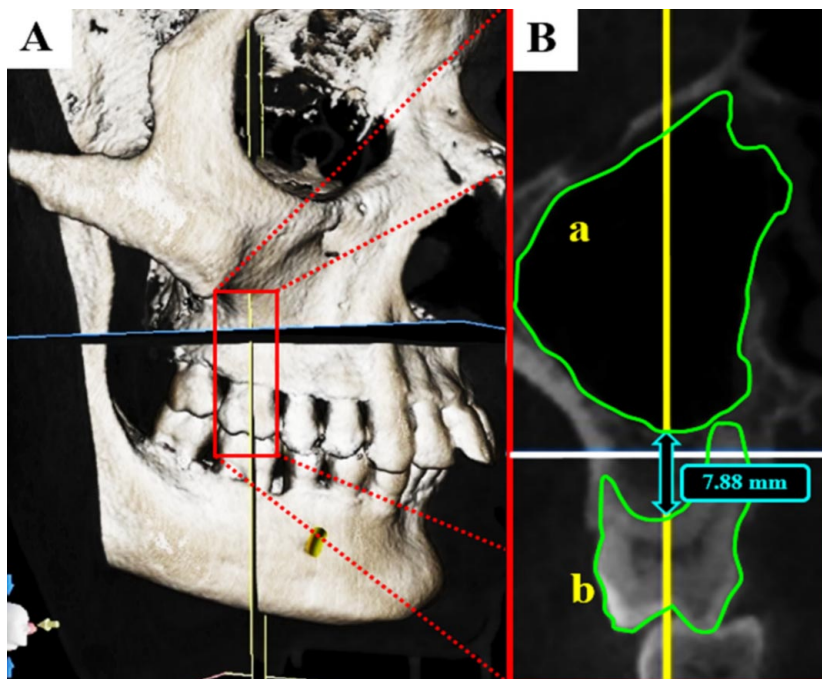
Cone-beam computed tomography of the skull. A. 3D representation of the skull CT scan, B. Coronal section of computed tomography showing a. Maxillary sinus and b. Upper first molar.
